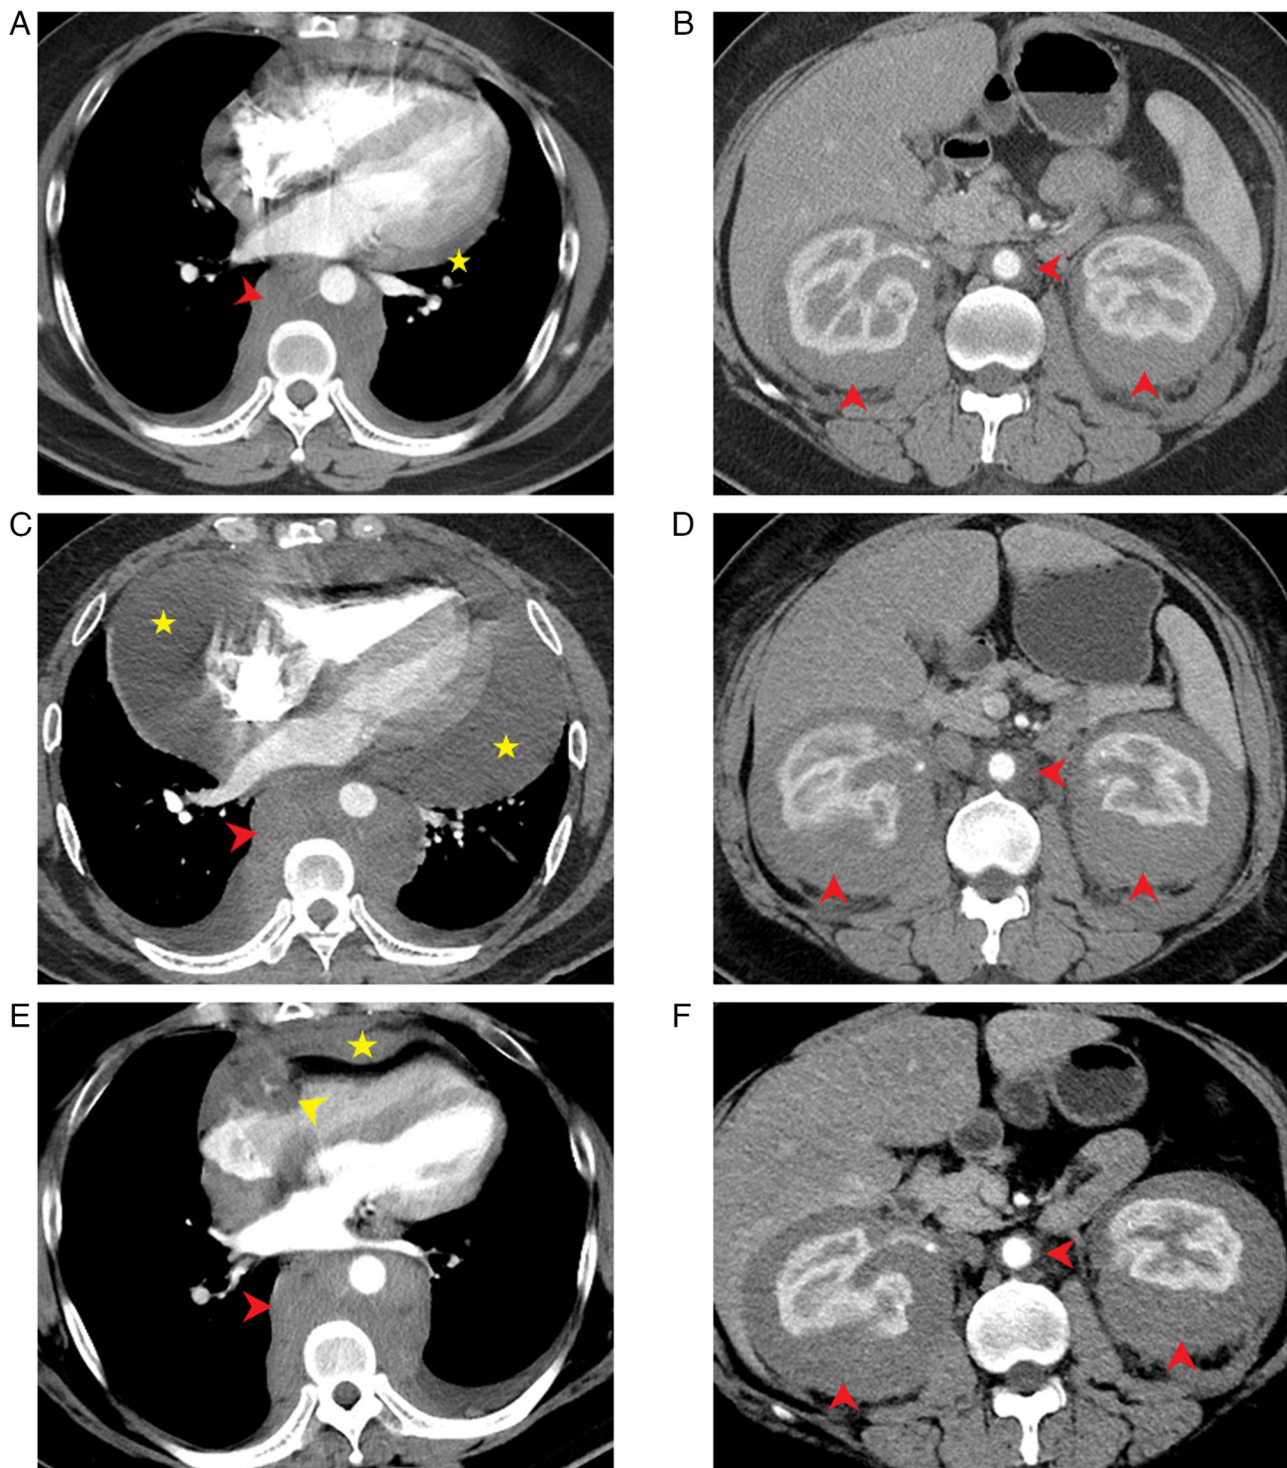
T2-weighted computed tomography images (axial view) of the chest and abdomen. (A and B) Images from 2017 showing the muscle-isodense tissue (red arrow) encircling the thoracic-abdominal aorta, the heart, and both kidneys, and a mild pericardial effusion (yellow star). (C and D) Images from 2021 showing a significant increase of tissue lesions (red arrow) and pericardial effusion (yellow star) compared with images from panels A and B. (E and F) Images from February 2023 showing lesions (red arrow) around the thoracic and abdominal aorta and pericardial effusion are reduced compared with images from panels C and D. A thickening of the lateral wall of the right heart (yellow star), pseudotumor, in the right atrioventricular groove, encircling the right coronary artery (yellow arrow), and significant compression of the heart.
